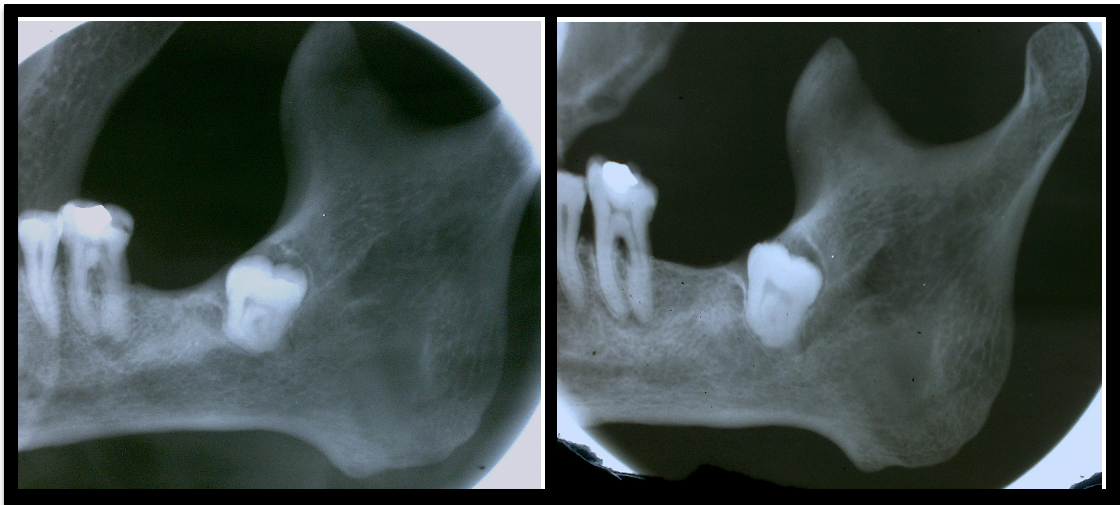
Two lateral oblique radiographs obtained of each third molar with a changed vertical angle (0° and -30° , respectively).
